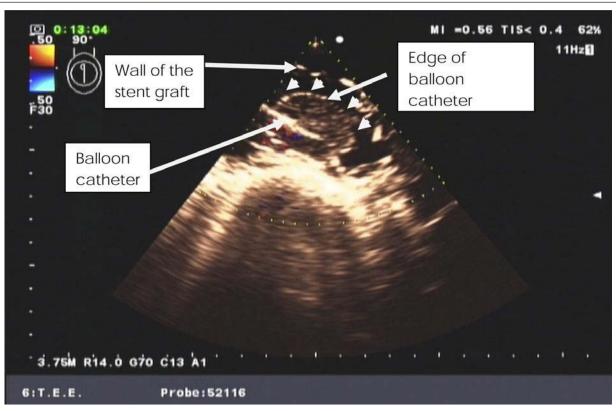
Intraoperative transesophageal image of the balloon catheter partially inflated in the descending thoracic aortic aneurysm.
